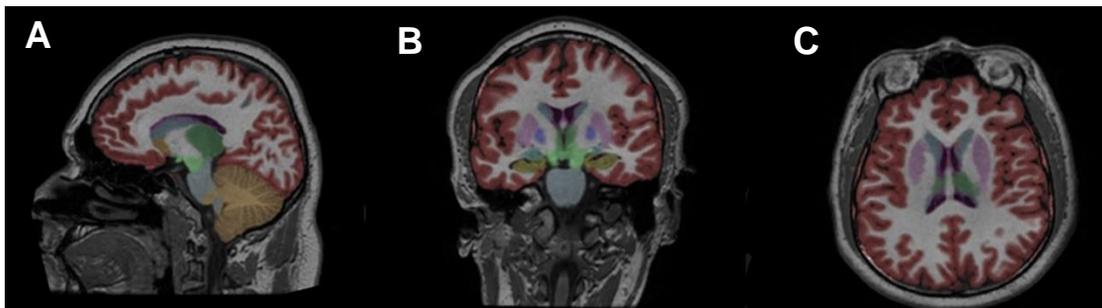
Representative image of a sagittal, coronal, and axial T1 MRI of a 24-year-old male diagnosed with mTBI. Images were processed using NeuroQuant 3.0 (Note: that in the above image slices each neuroanatomical sub-region is defined with a different color).
